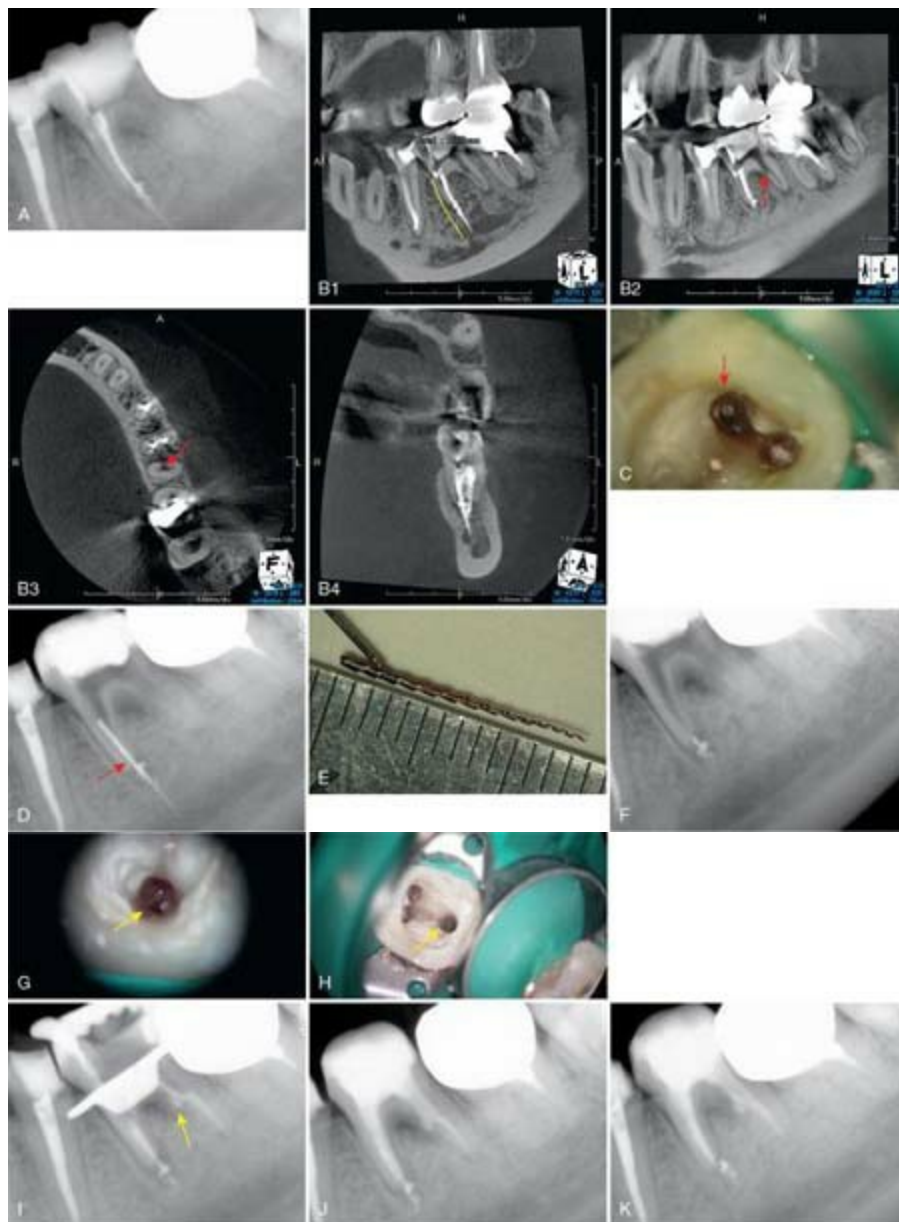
A, Radiograph of the mandibular left first molar with a long indistinct separated instrument obviously longer than 4.5 mm in the mesial root that is extruded beyond the radicular foramen. B1, Sagittal view of cone-beam computed tomography (CBCT) showing the radicular end of the separated instrument is extended into the IAN and it measures 14 mm on it. B2, Sagittal view of CBCT showing root perforation in the distal canal (*red arrow*). B3, Axial view of CBCT showing the perforation in the distal canal (*red arrow*). B4, Coronal view of CBCT showing the radicular end of the separated instrument is in the IAN. C, Separated instrument in the mesiobuccal canal upon removal of root filling materials (*red arrow*). D, Radiograph showing removal of the root fillings in the mesiobuccal canal revealed the overall length of the separated instrument (*red arrow*). E, Retrieved separated
